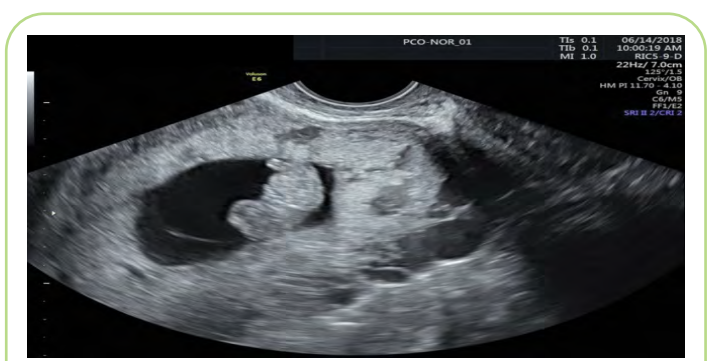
Ultrasonographic evaluations, the fetus continued to have fetal heart tones and appropriate fetal growth.
